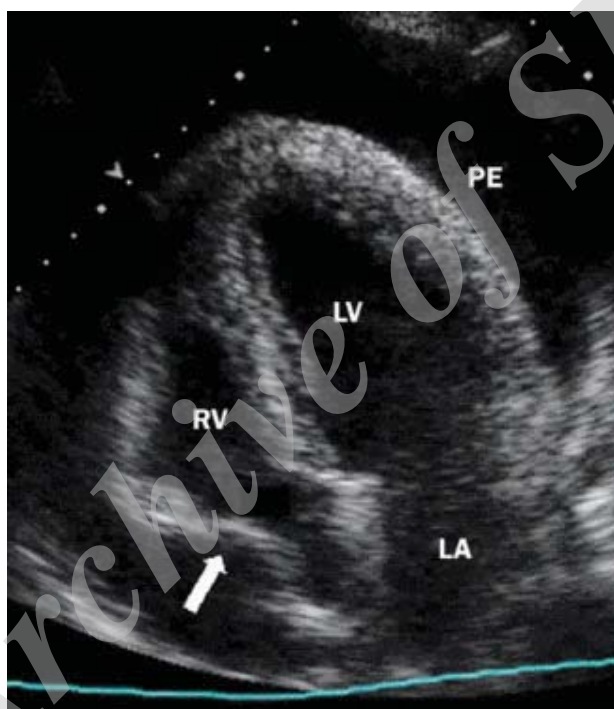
Trans-thoracic echocardiography showed significant pericardial effusion.
